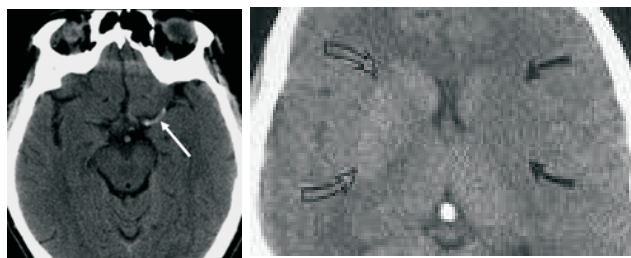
a) Axial CT b) Magnified CT
